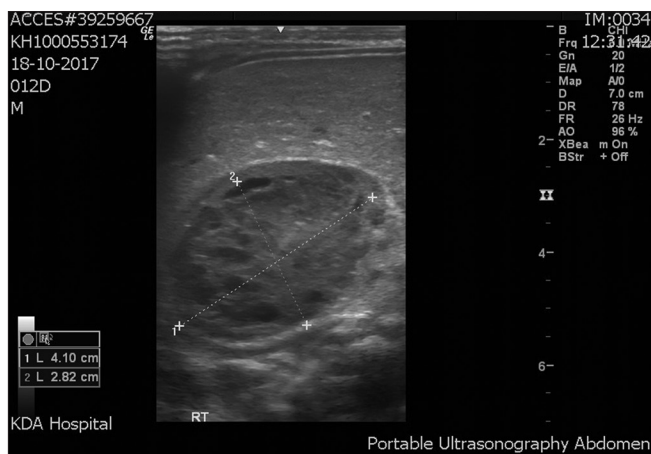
Adrenal hemorrhage on ultrasonography
